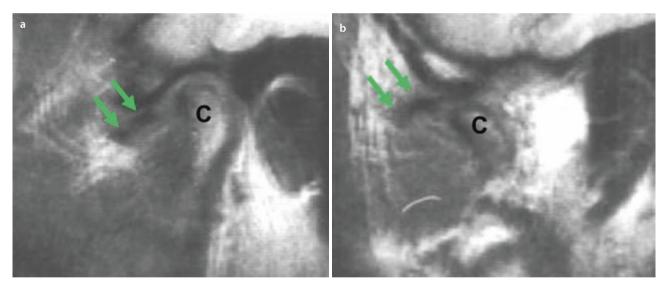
a MRI coronal view demonstrates a medially displaced articular disc. Notice the decreased vertical joint space toward the lateral aspect of the fossa. b Coronal view demonstrates lateral displacement of the articular disc. Medial joint space may be narrowed
